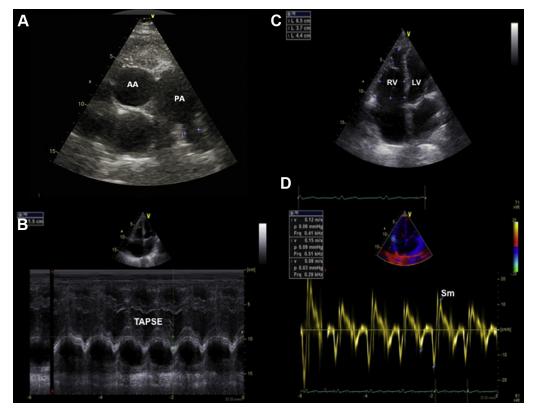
Standard echocardiography. A, Mild pulmonary artery enlargement. B, Right ventricular enlargement, with normal function by (C) tricuspid annular plane systolic excursion and (D) tissue Doppler analysis.
